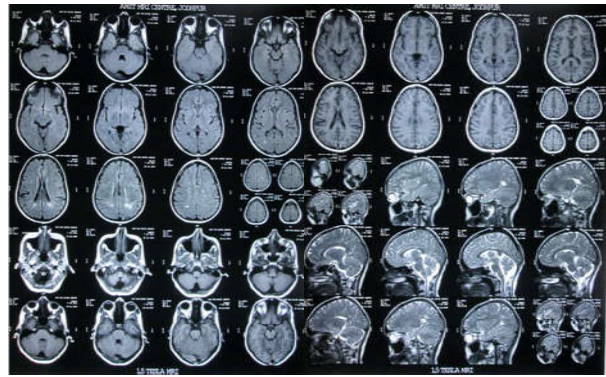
MRI Brain showing demyelination in deep white matter and periventricular area in parietal and occipital lobes
